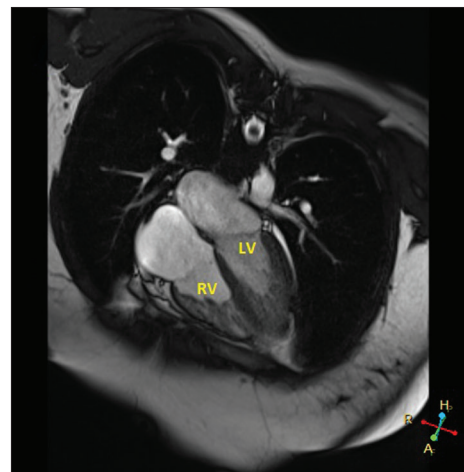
Cardiac magnetic resonance imaging in the transverse view, revealing noncompaction parts in the left and right ventricles. LV, left ventricle; RV, right ventricle
